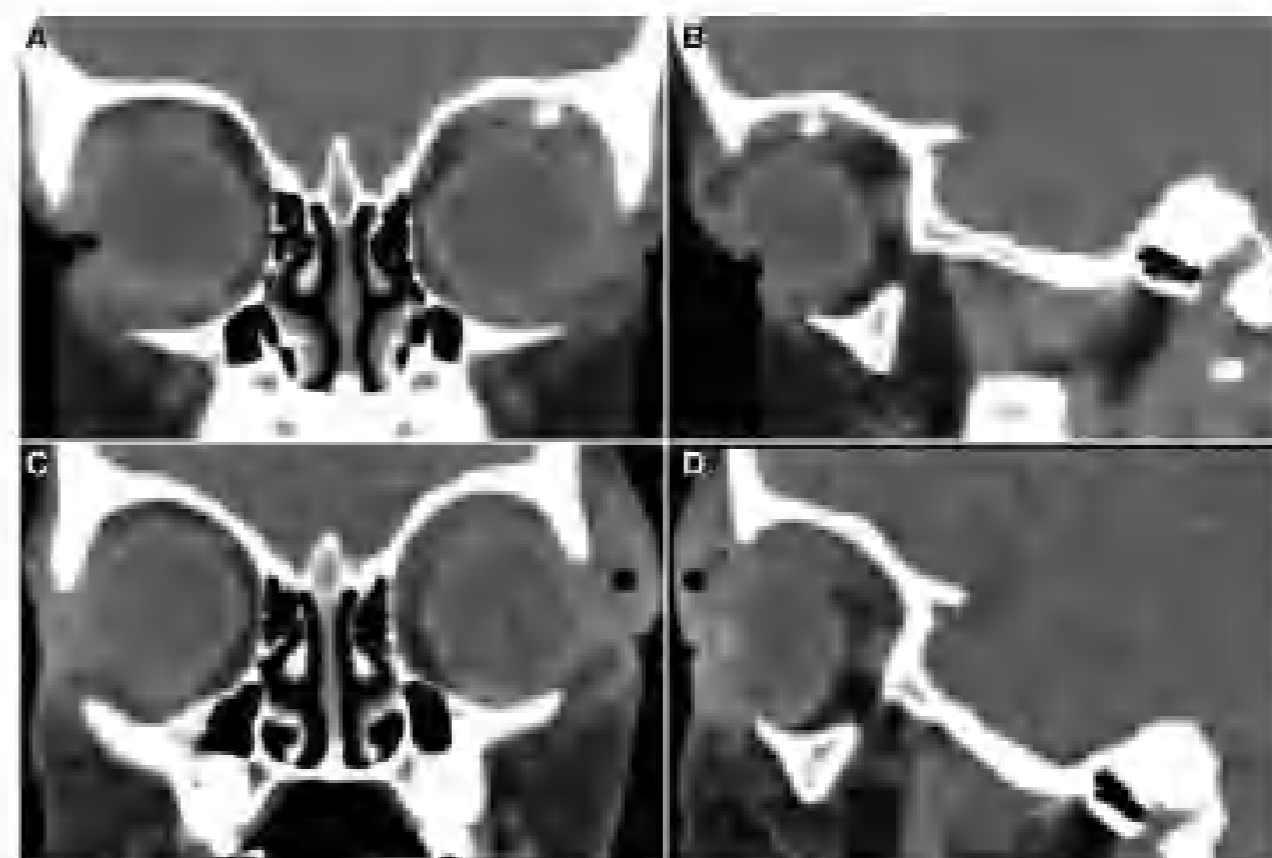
A, B. Initial computed tomography revealed a radiopaque foreign body within the superotemporal wall surrounding inflammation in the globe and the retrobulbar fat. C, D. The included image body in the large amount of inflammatory change.
